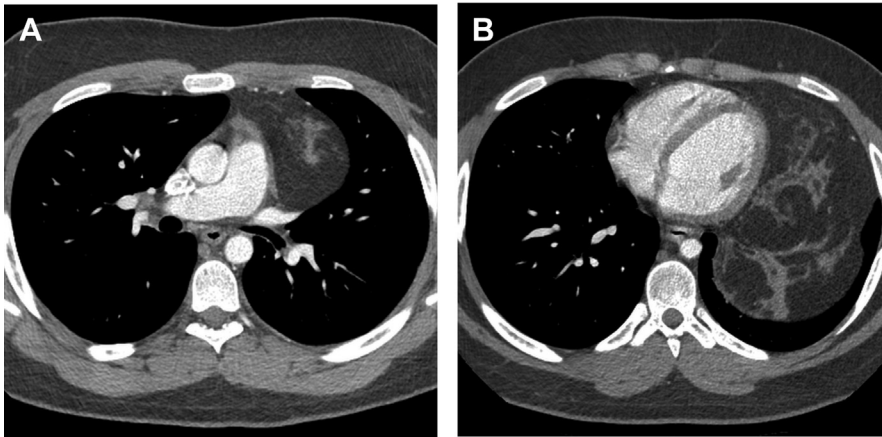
Thymolipoma (A, B). Contrast-enhanced axial CT of the same patient at a more superior (A) and more inferior (B) level of the mediastinum shows a large heterogeneous mass in the left prevascular mediastinum that exhibits fat and soft tissue attenuation, corresponding to adipose and thymic tissue, respectively. Note the anatomic connection of the mass to the thymic bed (A), which strongly supports the diagnosis of thymolipoma.
